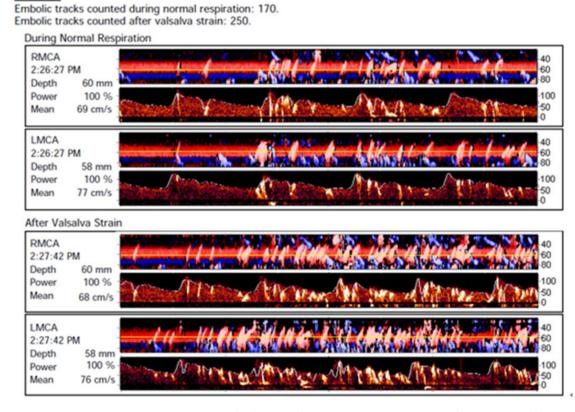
Transcranial doppler sonogram indicated that many microembolic signals were detected during Valsalva maneuver as well as normal respiration
